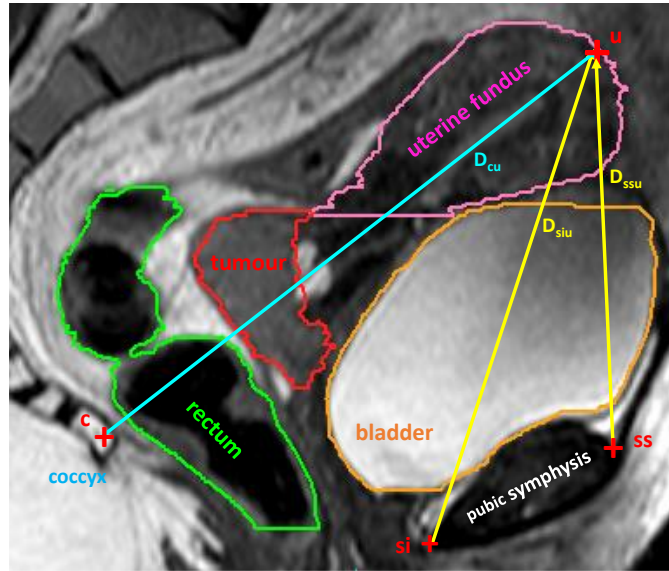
Sagittal image of a T2-weighted MRI that shows the delineated volumes (rectum - green, uterus - pink, bladder - orange, tumour - red), the reference points (coccyx - c, pubic symphysis - ss, si, external uterine fundus - u) and the calculated distances (D_{cu} - distance from the coccyx to the uterine fundus, D_{ssu} - distance from the superior symphysis to the uterine fundus, D_{siu} - distance from the superior symphysis to the uterine fundus)
